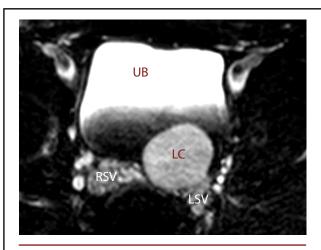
T2-weighted magnetic resonance image showing a left seminal vesicle cyst and a normal right seminal vesicle
